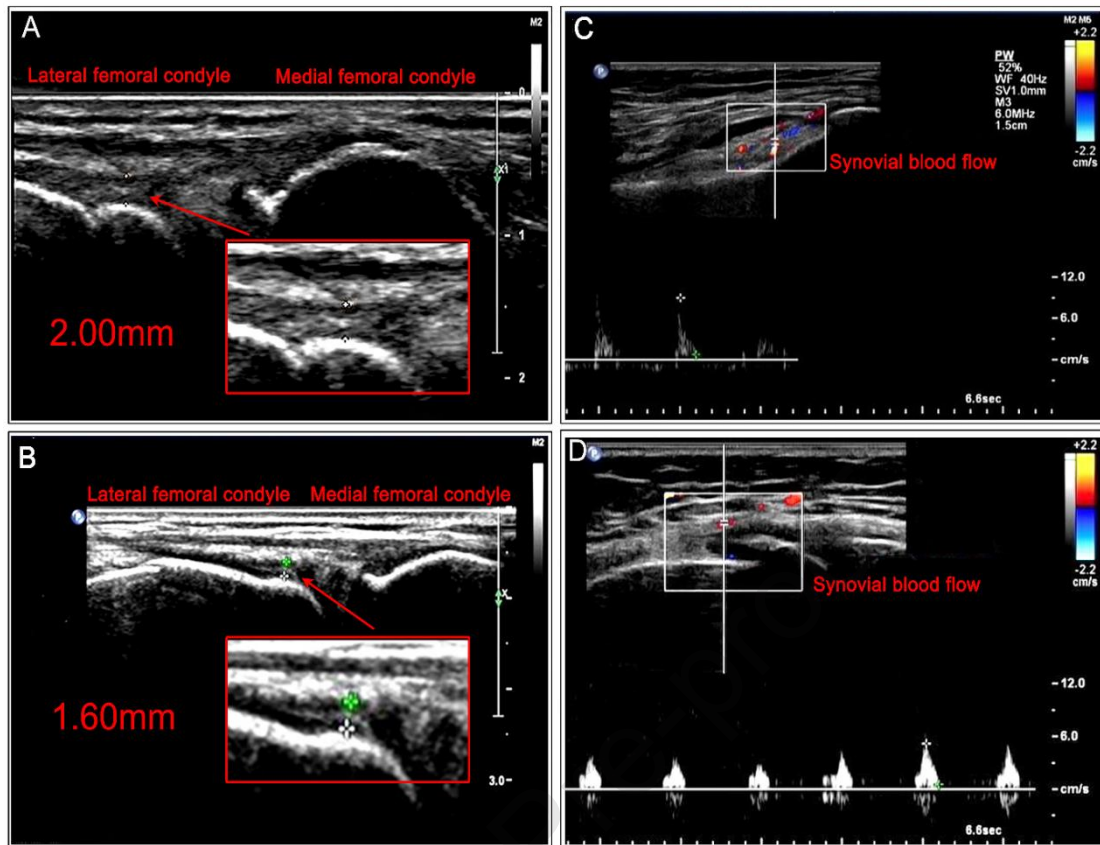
(A) High-frequency color Doppler imaging results demonstrated an improvement in synovial hyperplasia of the medial and lateral femoral condyle in the PRP and PRP+HA groups 6 months after injection ( $P < .05$ ), with more obvious improvement in the PRP+HA group ( $P < .05$ ). (B) No significant change in the thickness of the medial or lateral femoral condyle cartilage was observed in the three groups ( $P > .05$ ). (C) No significant change in the depth of effusion in the suprapatellar bursa or deep infrapatellar bursa was observed in the three groups ( $P > .05$ ).
